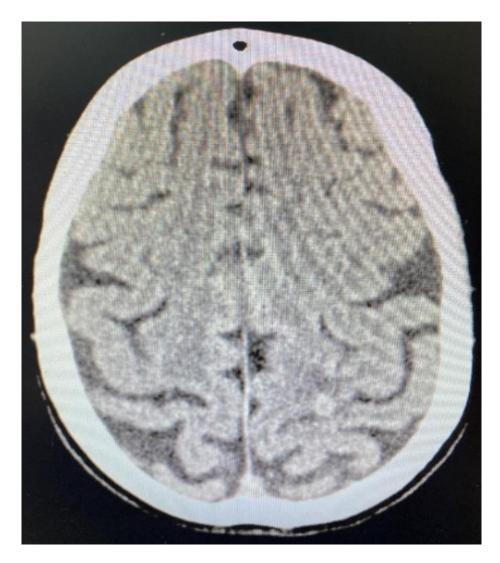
Brain CT revealing left-high parietal metastasis (5 mm) with small perilesional edema
